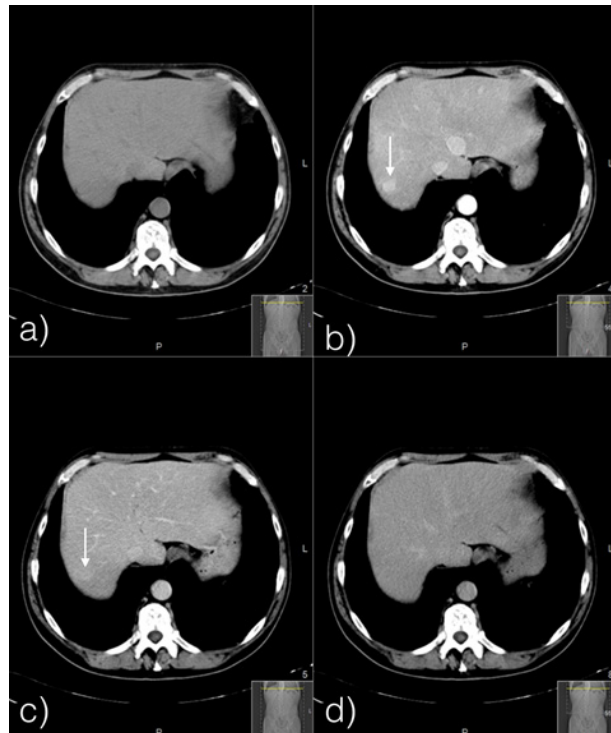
Contrast enhanced abdominal CT depicting the nodule in segment 7 – the nodule (arrow) has similar behavior to the nodule in figure 2.
